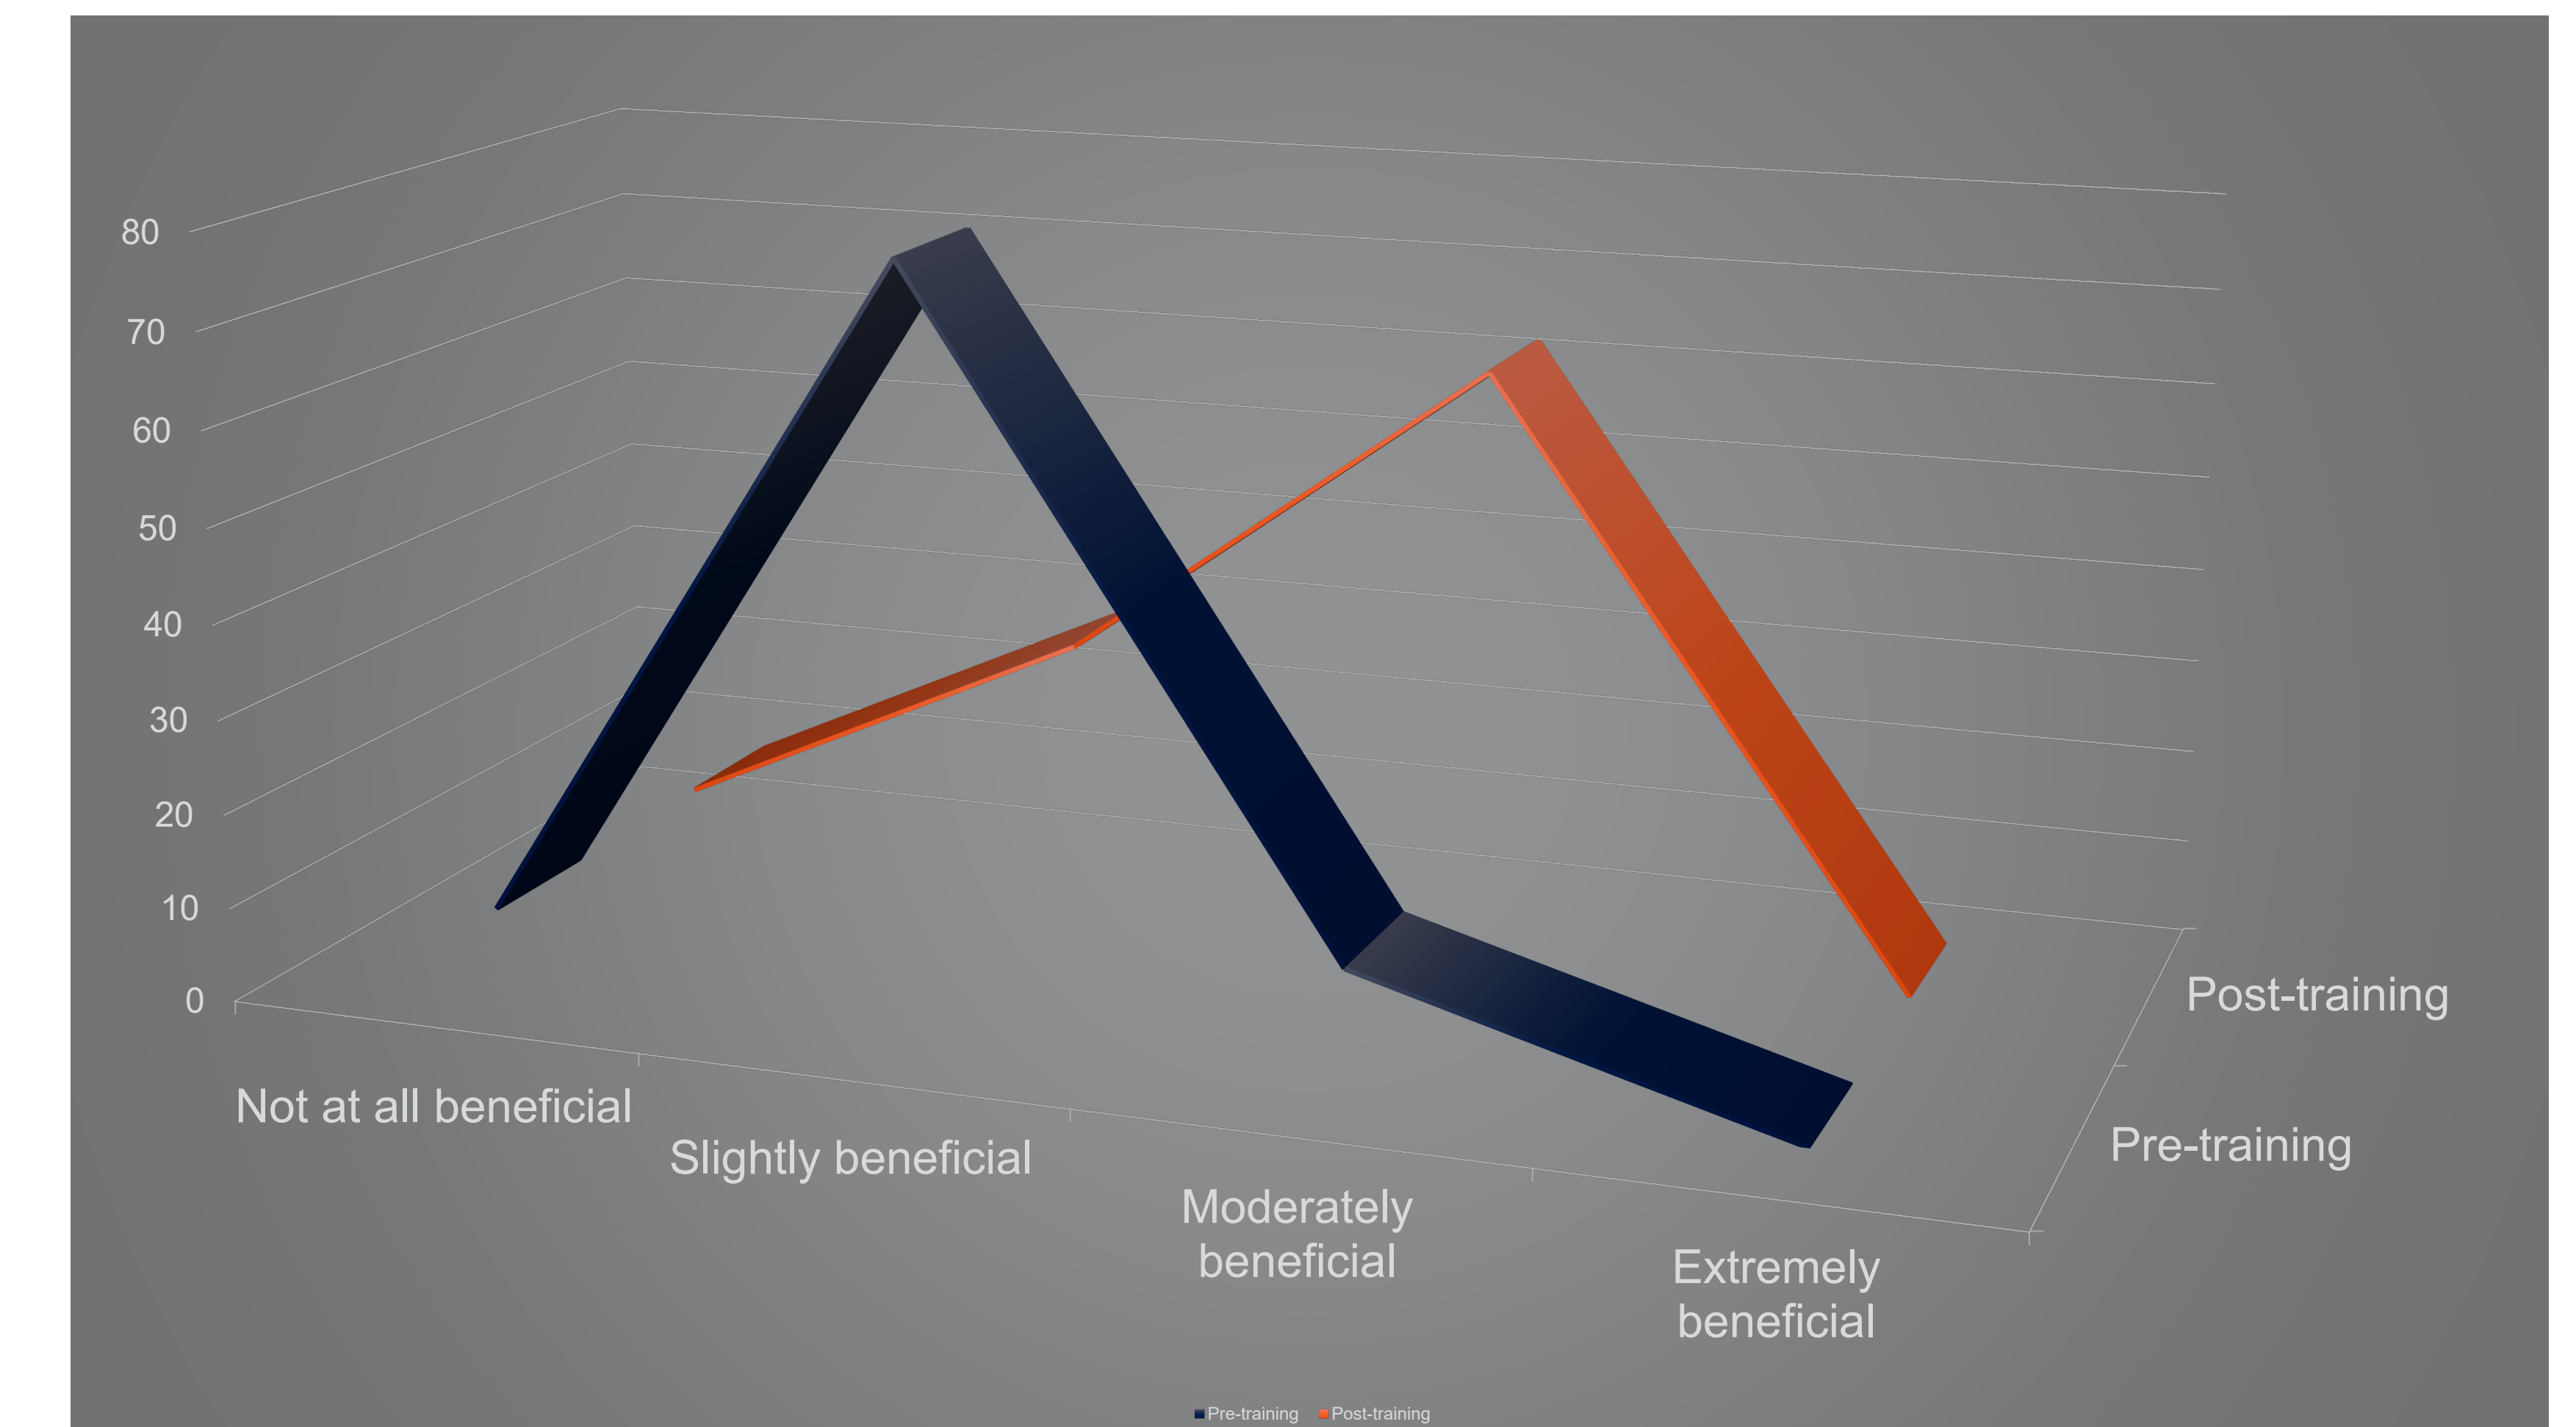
How beneficial do you think bedside ultrasound is for patient care?
